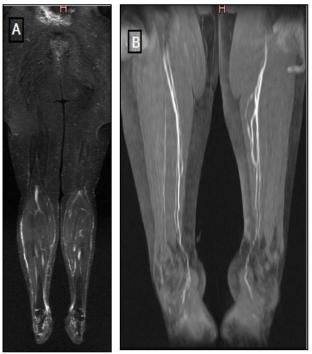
(A) Coronal MRI STIR shows bilateral mild edema more at right side. (B) Cronal MRI post-contrast T1 fat supression shows dilated lymphatic channels at right side and faint dilated lymphatic channels at left side.
